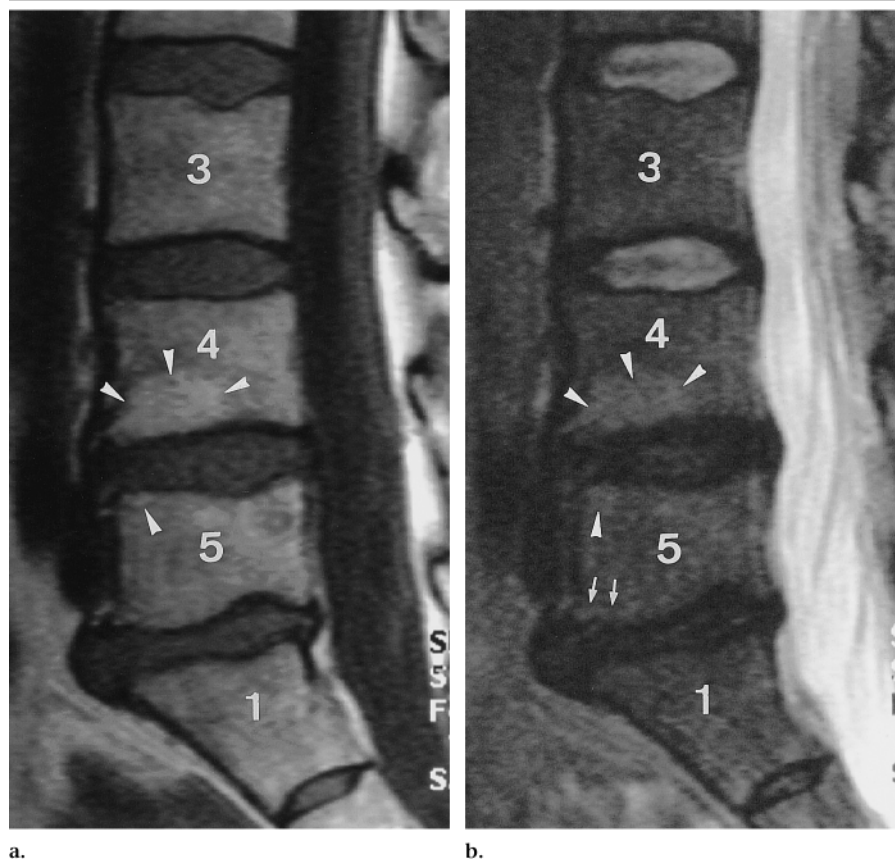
MR images of the lumbar spine in a 46-year-old woman with discogenic low back pain demonstrate the criteria used to identify moderate endplate abnormalities. Sagittal (a) T1-weighted (700/12) and (b) T2-weighted (5,000/112) MR images demonstrate a thick semicircular band of increased signal intensity (upper arrowheads) of bone marrow adjacent to the upper aspect of the endplate at the intervertebral disk level of L4 (4) to L5 (5) (cranial or caudal extent between 25% and 50% of the vertebral height measured on a midsagittal image) and a small focus of increased signal intensity (lower arrowhead) of marrow at the inferior aspect of this level. Image findings are consistent with a moderate type II endplate abnormality. There is grade 3 degeneration at the L4-to-L5 intervertebral disk level with disk bulging and grade 4 degeneration at the intervertebral disk level of L5 to S1 (I) with mild type II endplate abnormalities (arrows in b) and disk bulging. 3 = L3 vertebra.
